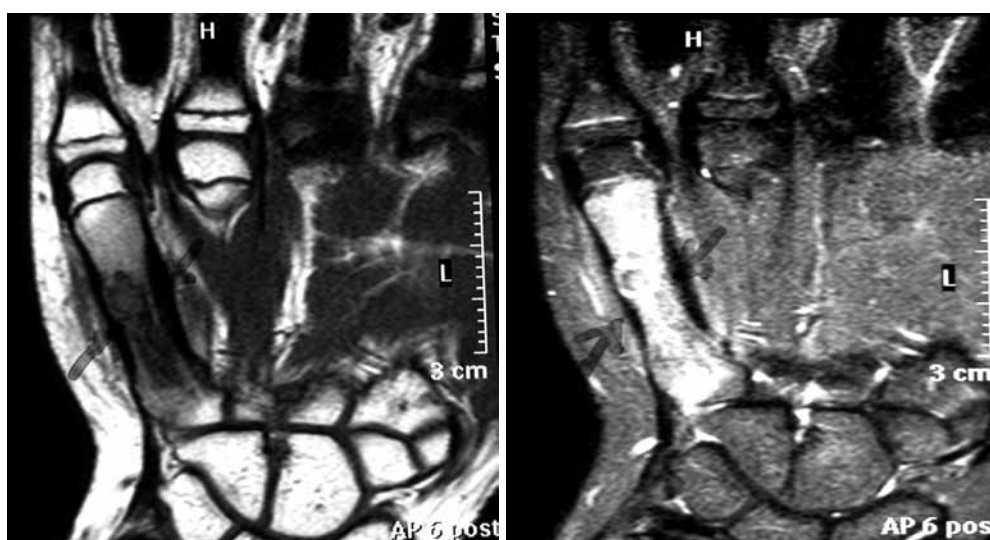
T1 and T2 sections of magnetic resonance imaging of the case.
